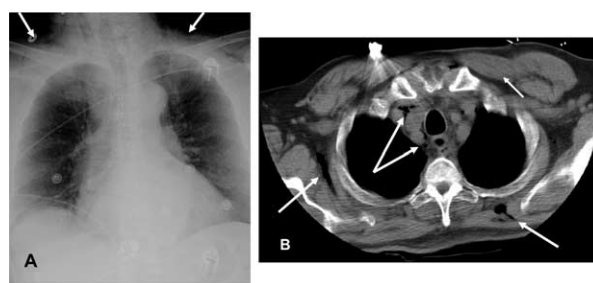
(A) Chest roentgenogram demonstrating significant neck subcutaneous emphysema (*arrows*). (B) Chest CT revealing air collections in the mediastinum and adjacent to the thoracic wall (*arrows*).
